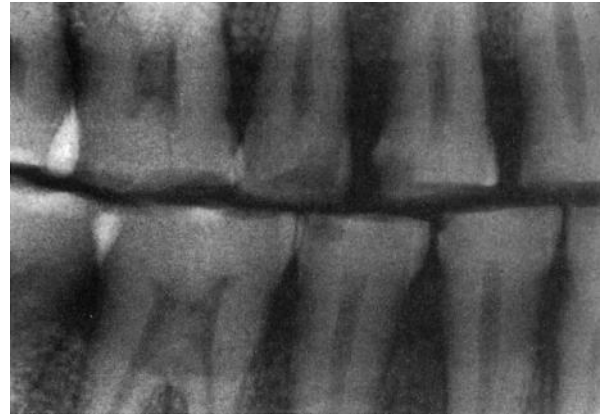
Attrition or mechanical wear of the masticatory surfaces of the permanent teeth in this case is noted on a radiograph. The result is a loss of the curvatures of the teeth within the dental arches. (Courtesy of Margaret J. Fehrenbach, RDH, MS.)
